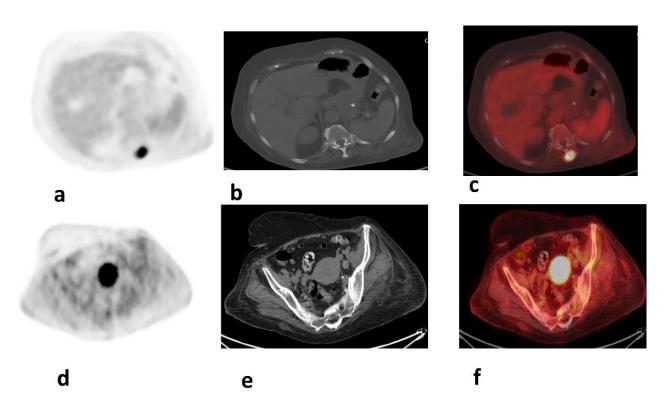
Case 1: axial views: a, b& c images showing metabolically active lesion at the spine of the 10th dorsal vertebra; a PET image, b CT image, c fused image, d, e& f images showing FDG avid uterine mass; d PET image, e CT image, f fused image
